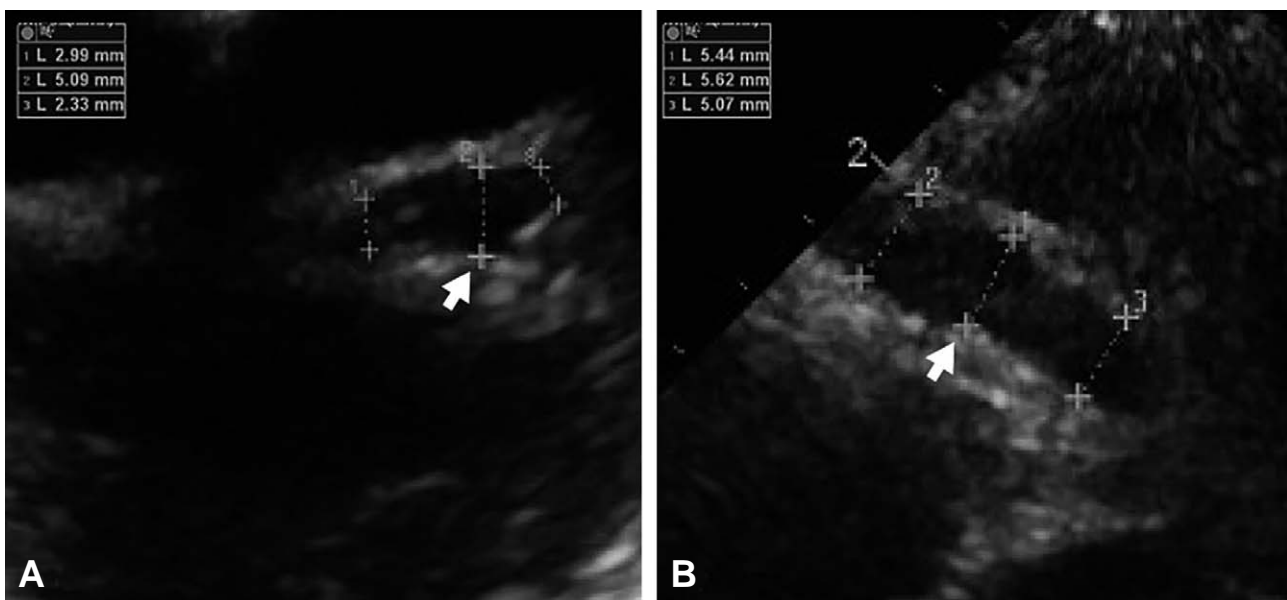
Echocardiographic findings after the first intravenous immunoglobulin therapy. It shows the left main coronary artery and proximal portion of the dilated left descending artery (arrow; diameter, 4.3–5.1 mm; Z-score = 5.0) (A) and a fusiform diffuse dilatation of the right coronary artery (arrow; diameter, 5.6–6.0 mm; Z-score = 5.1) (B).
